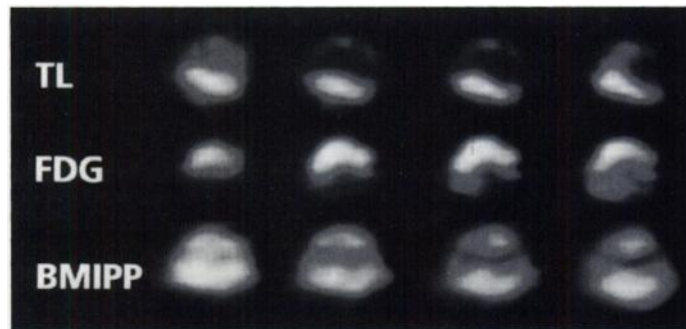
Patient (37-yr-old woman) with an old anterior myocardial infarction, 4 yr earlier. The vertical long-axis shows a severe perfusion defect in the anterior wall, with both a FDG/perfusion and a BMIPP/perfusion mismatch.
